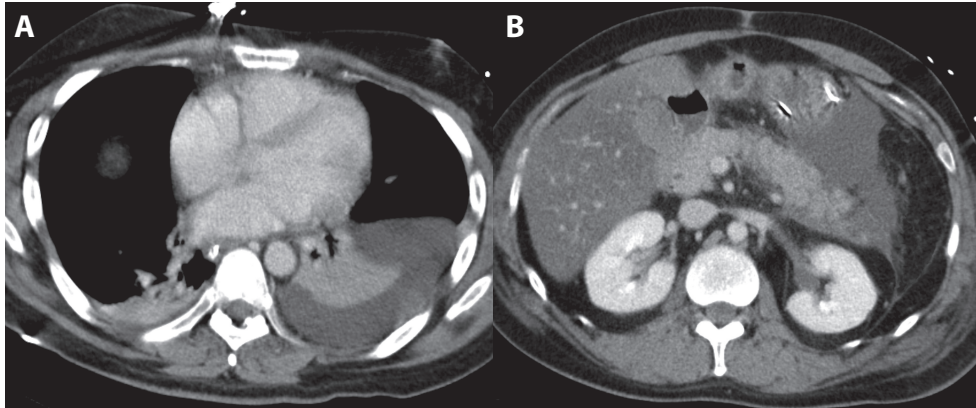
46-year-old woman with acute pancreatitis. A, Axial contrast-enhanced CT scan shows presence of bilateral pleural effusions with atelectasis of lower lobes. B, Axial contrast-enhanced CT scan shows one peripancreatic fluid collection and slightly heterogeneous enhancing pancreatic parenchyma without apparent areas of nonenhancement. Score was 3 (morphologic mild pancreatitis) on CT severity index and 6 (morphologic moderate severe acute pancreatitis) on modified CT severity index. Patient survived but experienced persistent organ failure and, thus, was diagnosed with clinically severe acute pancreatitis.
